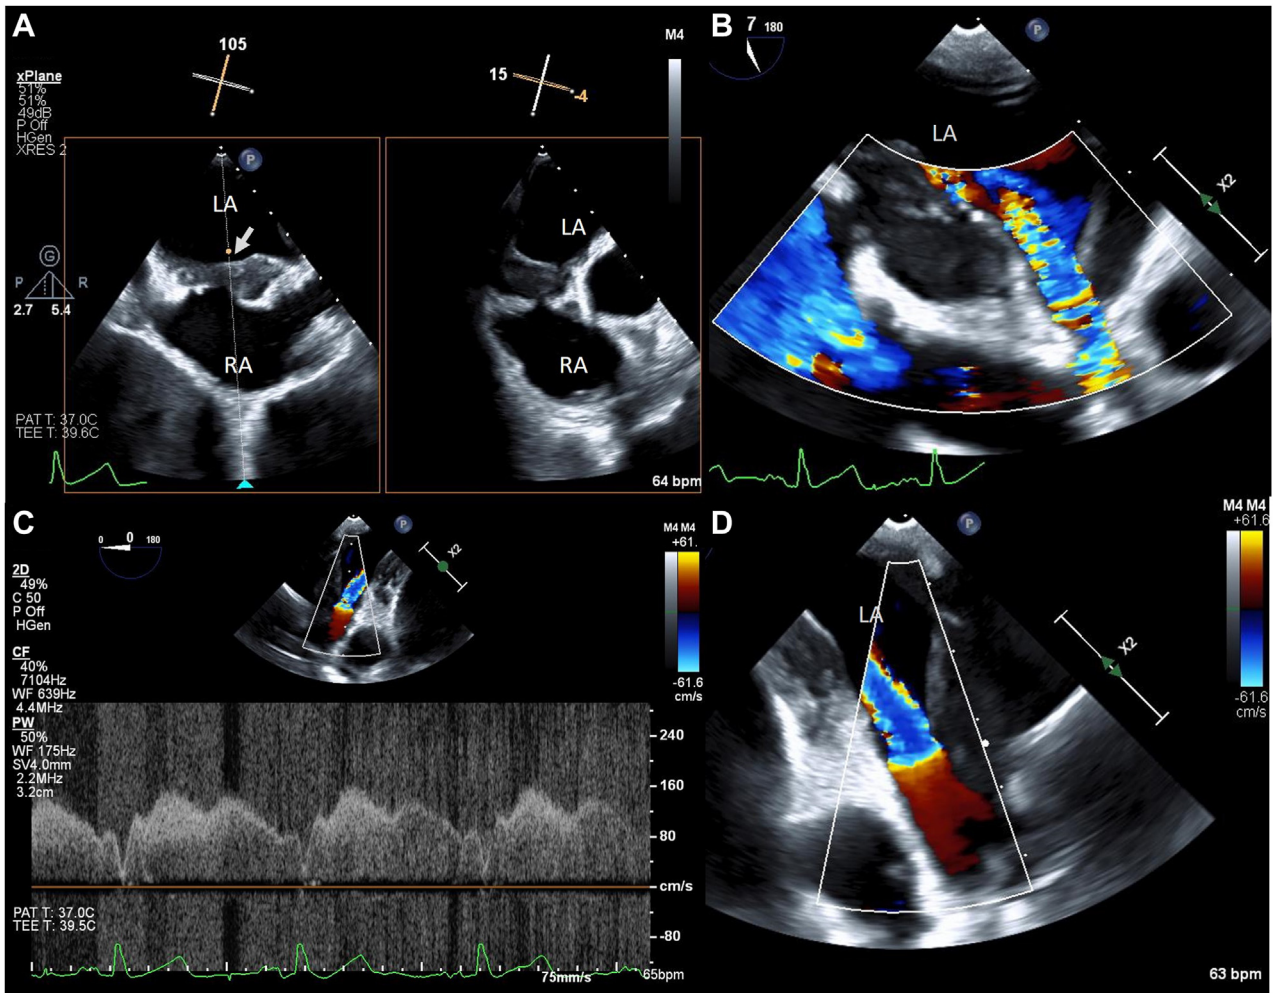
Intraoperative two-dimensional transesophageal echocardiogram, bicaval biplane (A) long-axis (*left*) and short-axis (*right*) view, demonstrates a mass (*arrow*) at the interatrial septum in cross plane; (B) rightward rotated, long-axis (117°) view with reduced Nyquist color-flow Doppler and (D) long-axis (103°) view with normal scale color-flow Doppler, demonstrates right superior PV stenosis; (C) short-axis display (0°) with color-flow Doppler-guided pulsed-wave spectral Doppler, demonstrates a pathologic continuous flow pattern and increased maximal systolic velocity at 1.6 m/sec.
